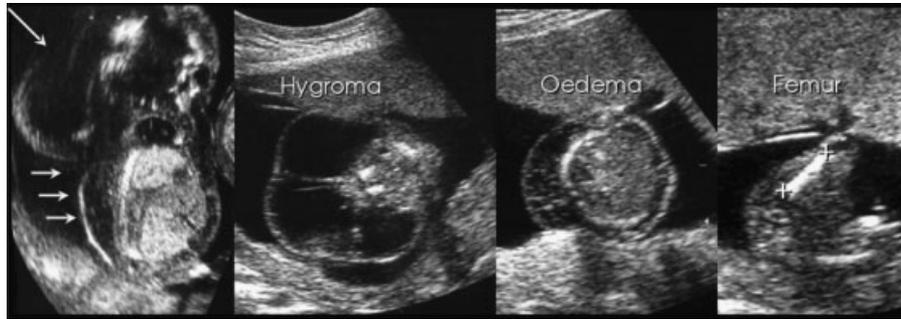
Ultrasound scan of fetus 2. Note large and septated nuchal cystic hygroma (arrows; longitudinal and axial scans) and short femur.
